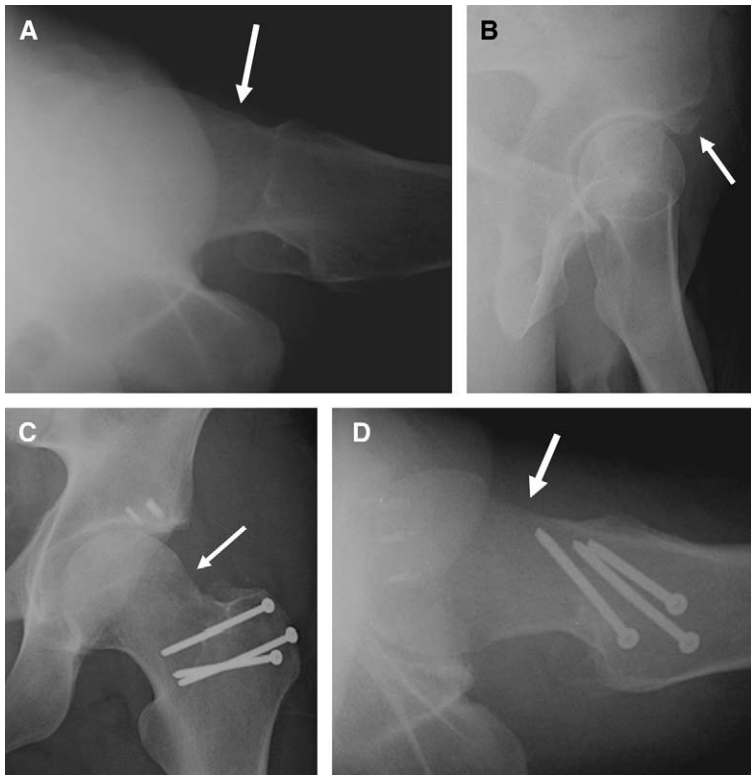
Treatment of Cam-type FAI. (A) A groin lateral showing a “bump” at the femoral head-neck junction (arrow). The false profile view (B) shows a very large os acetabulum (arrow). The postoperative anteroposterior (C) and groin lateral (D) radiographs show the resection osteoplasty at the femoral neck (arrow in both). The os acetabulum has been removed, and the labrum repaired (note the suture anchors at the acetabular rim). The screws in the greater trochanter secure the trochanteric osteotomy, which provided the surgical approach.
